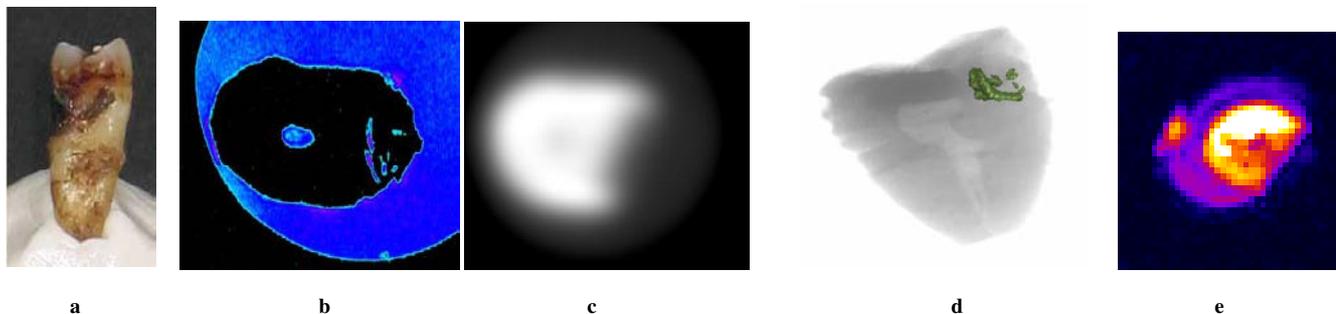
The photo image (a), corresponding cross-sections through 3D SE MR (b) and 3D CT (c) images and the pseudo 3D reconstruction (d) of the decayed tooth, obtained from 3D SE MR data. In fig (e) 2D cross-section from 3D SPI data of tooth with decay comparable to that for SE images is shown.
